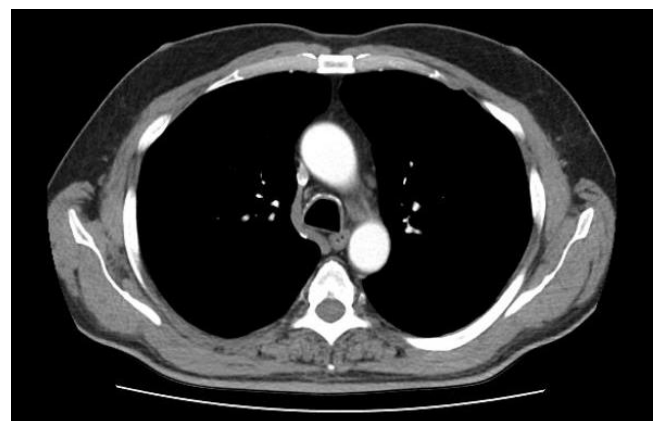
Thorax CT appearance at 1-year postoperative follow-up
